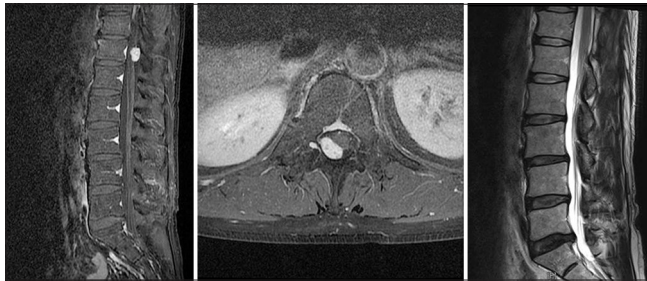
A contrast-enhanced intradural-extramedullary tumor was identified at the T12 level on sagittal (left), axial (middle) T1-weighted images, and postoperative T2 sagittal image (right)
